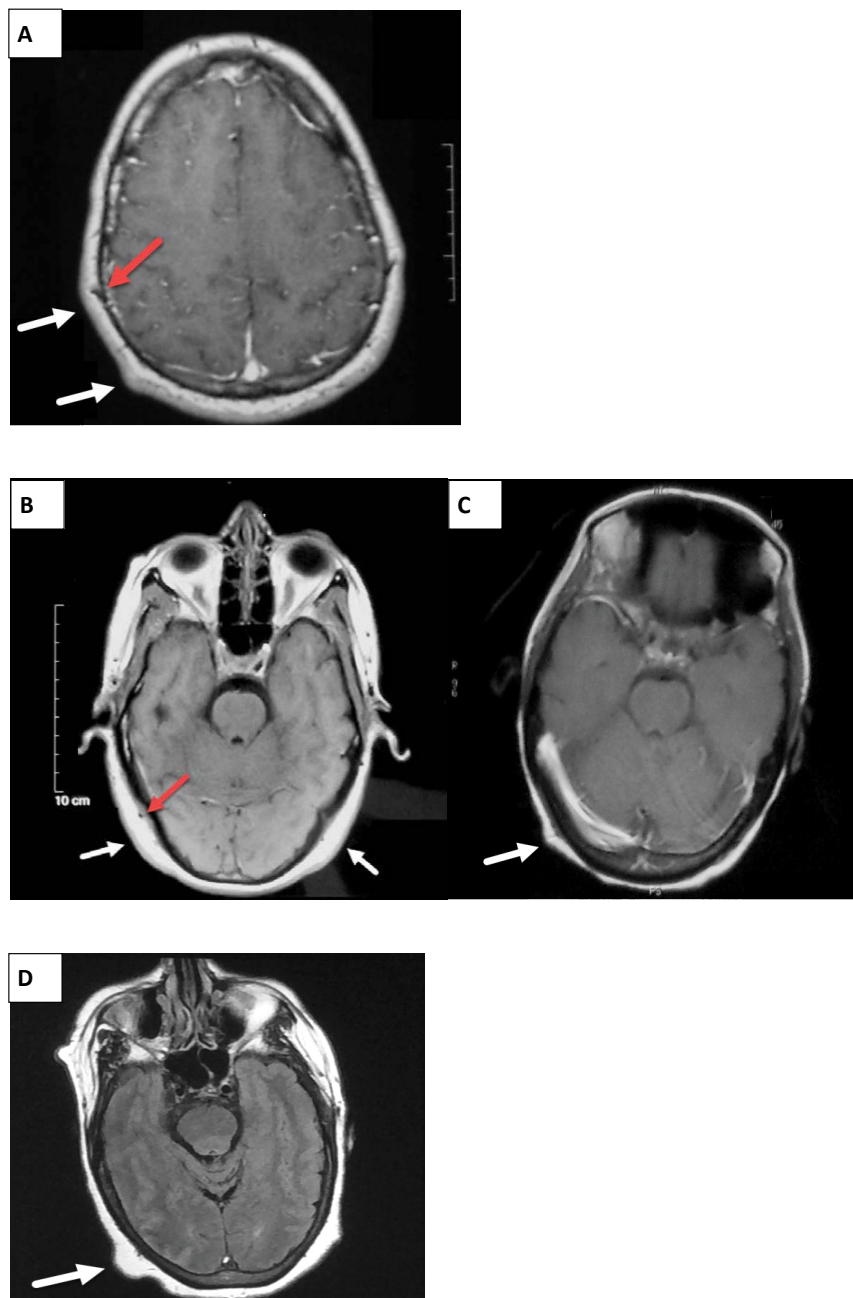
Brain MRI: A) White arrows: Stage 1 scalp oedema: Thickening of the scalp not exceeding double its thickness; Red arrow: Congestion of emissary veins; B) White arrows: Stage 2 scalp edema: Thickening of the scalp exceeding double but not more than three times its thickness; Red arrow: Congestion of emissary veins. C) Detachment of the scalp from the bone, Red arrow: Congestion of emissary veins; D) White arrow: Stage 3 scalp oedema: Thickening of the scalp exceeding three times its thickness.
